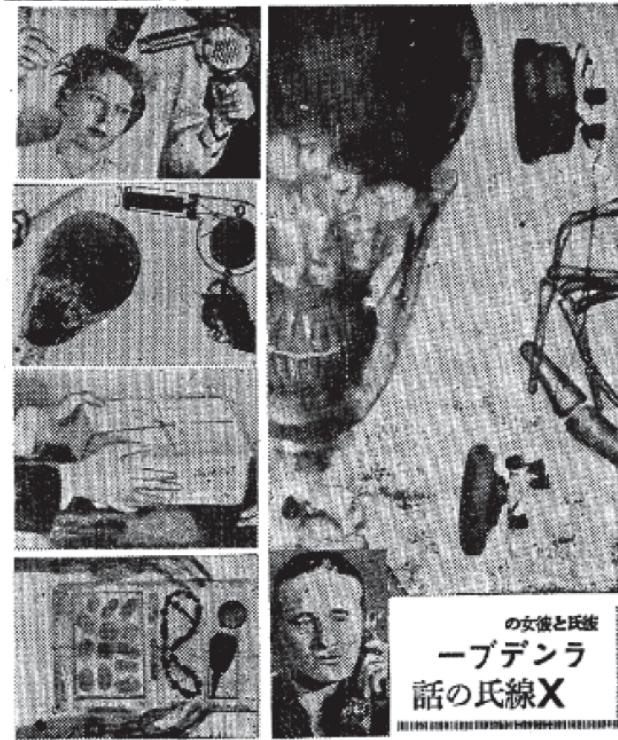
“Mr. and Ms. On a Rendezvous – the tale of Mr. X-Ray”, *Yomiuri shimbun*, 1937.
